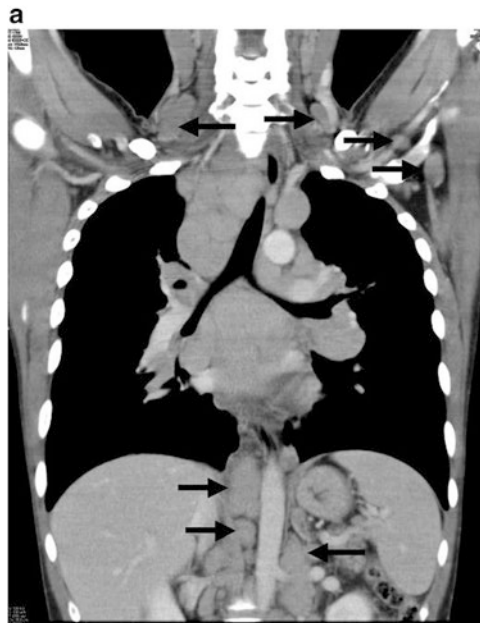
A CT scan showed supraclavicular, bilateral hilar, mediastinal, cervical, and abdominal para-aortic lymphadenopathy (*black arrows*) (a). ^{18}F -FDG-PET revealed increased uptake in corresponding areas (b). ^{18}F -FAMT showed no increase in uptake corresponding to these lesions (c) (Ref. [23])
